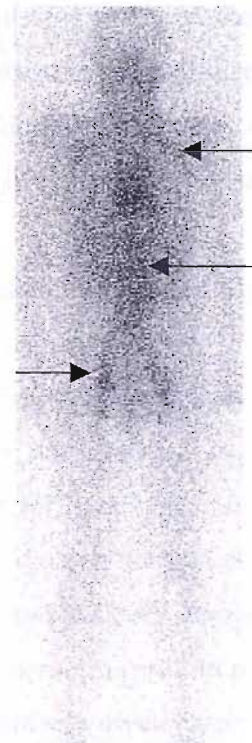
Gamma camera image taken on day 4 post dosimetric dose administered to patient SY without prior induction rituximab or pre-dose (A). Despite extensive nodal involvement documented on CT almost all the activity is concentrated in the mildly enlarged spleen. Following a course of induction rituximab and the predose the day 4 image in the same patient shows loss of the activity in the spleen with evidence of targeting of ^{131}I rituximab to axillary, abdominal and pelvic lymph nodes (arrows).
